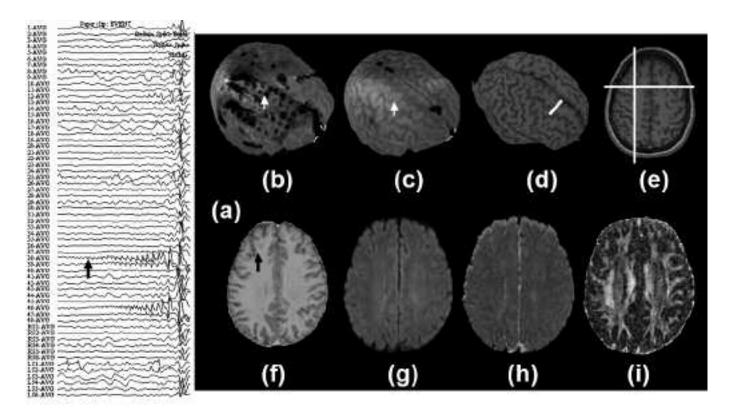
Region of interest placement in patients without obvious white matter abnormalities. Intracranial electroencephalogram (EEG) and MRI data for patient four. (a) Subdural grid recording demonstrating focal ictal EEG onset at electrode contact 38 (arrow) with subsequent spread to surrounding contacts 39 and 46. (b, c) Curvilinear reformatted volumetric T2 weighted MRI with subdural grid in place (b) superficial slice demonstrating location of grid and (c) deeper slice demonstrates underlying cortical anatomy (arrow indicates the location of contact 38). (d,e) Volumetric T1 weighted MRI (d) curvilinear and (e) axial slice. (d) The marker indicates trajectory line from corresponding location on axial slice. Curvilinear reformatted T1 weighted and T2 weighted (with grid in place) data was used to determine the region of interest on axial MRI. (f) Axial T1, (g) FLAIR, (h) trace ADC and (i) FA maps for patient four. (f) The arrow indicates subcortical white matter directly underlying the gyral abnormality. No obvious abnormalities are observed in the underlying subcortical white matter on FLAIR, trace ADC or FA for this patient.
